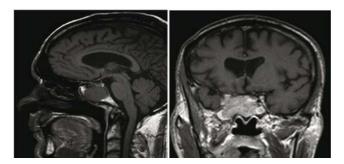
T2 MRI sagittal section: Lesion seen separate from pituitary, T2 MRI coronal section: Lesion in right sphenoid extending to right cavernous sinus, fully encasing the carotid artery
